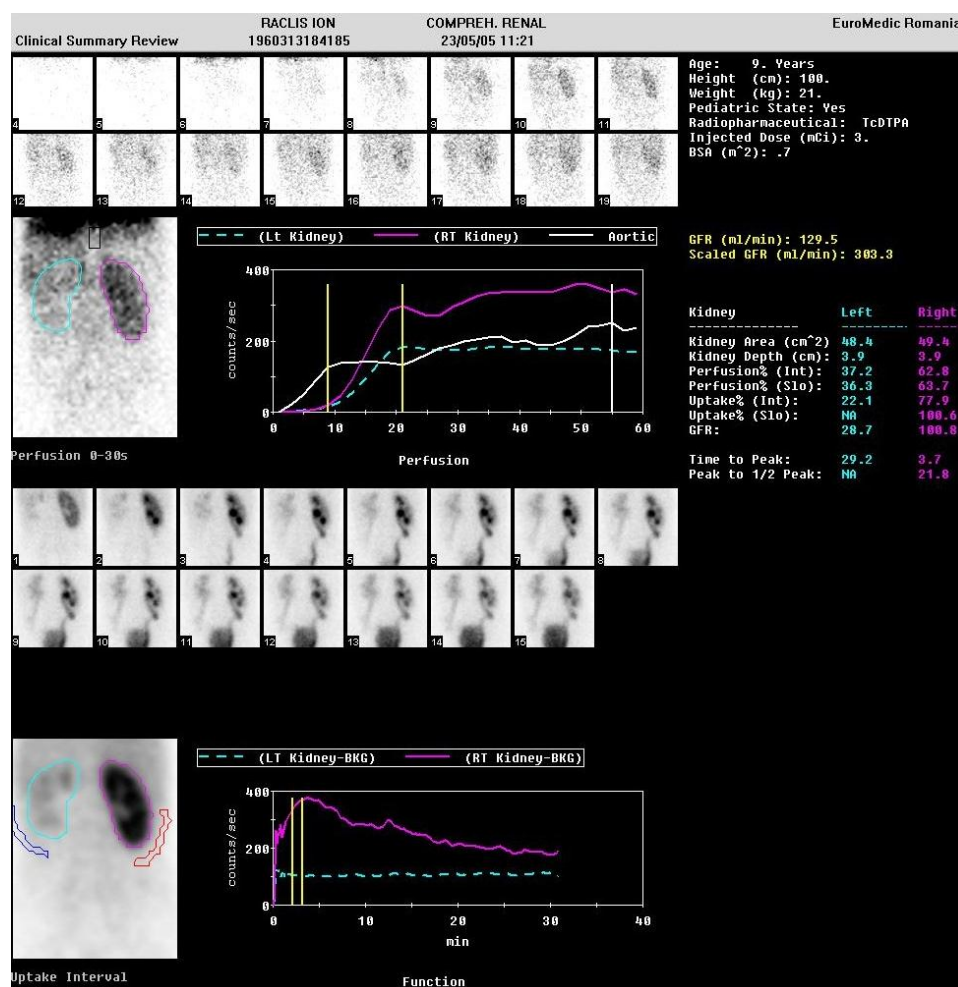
Dynamic renal scintigraphy with TcDTPA, VUR grade IV bilateral with bilateral megaureter. Glomerular filtration rate = 129.5 ml / min, curve type II O'Reilly - Collection of Pediatric Surgery Clinic Constanta
